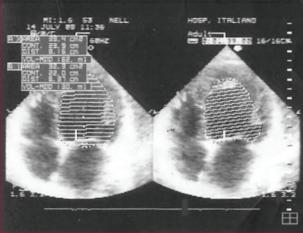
Pre-ablation echocardiogram.
